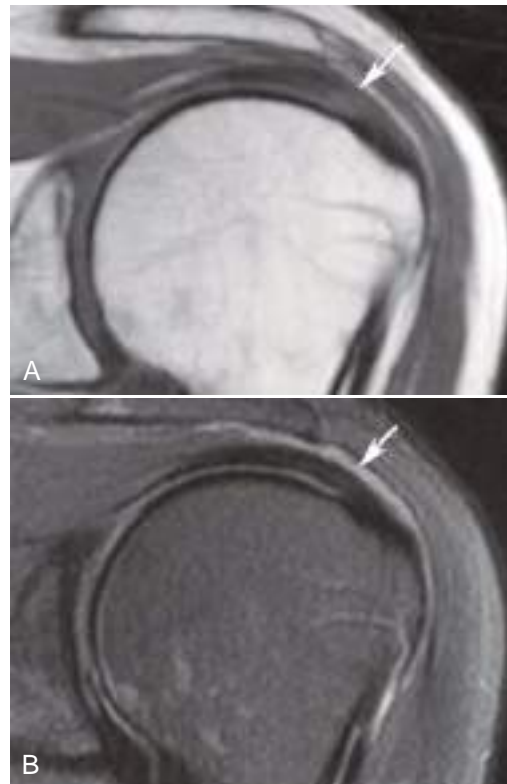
Magic angle effect. (A and B) Oblique coronal T1-weighted (A) and fat-suppressed fast spin-echo T2-weighted (B) (echo time effective, 60 msec) MR images show the normal curved course of the supraspinatus tendon over the humeral head. Images were obtained in a high-field magnet with β_0 -oriented head-to-toe. Note increased tendon signal in A but normal low signal in B, where the tendon is oriented about 55 degrees away from β_0 (*arrow*).
